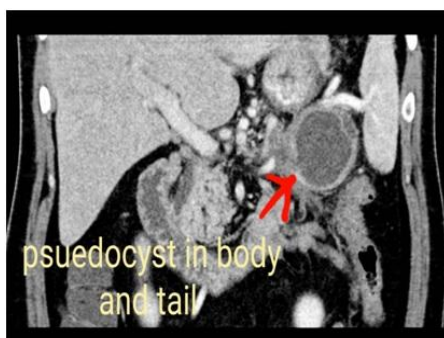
Contrast CT scan of abdomen and pelvis revealed laceration of pancreas grade III with pseudocyst in body and tail of pancreas.
